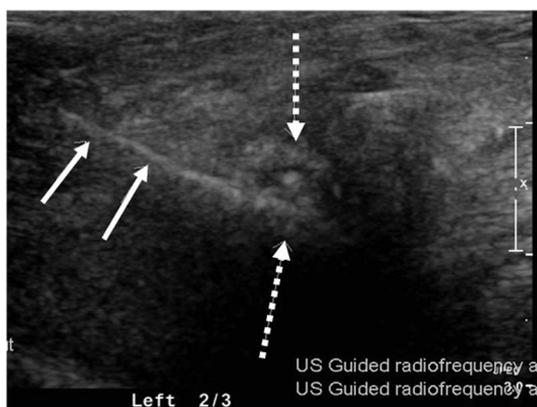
Echogenic ablation zone (dashed arrows) surrounding the radiofrequency cannula (straight arrows) seen following RFA of Morton's neuroma at ultrasound in the same patient.
